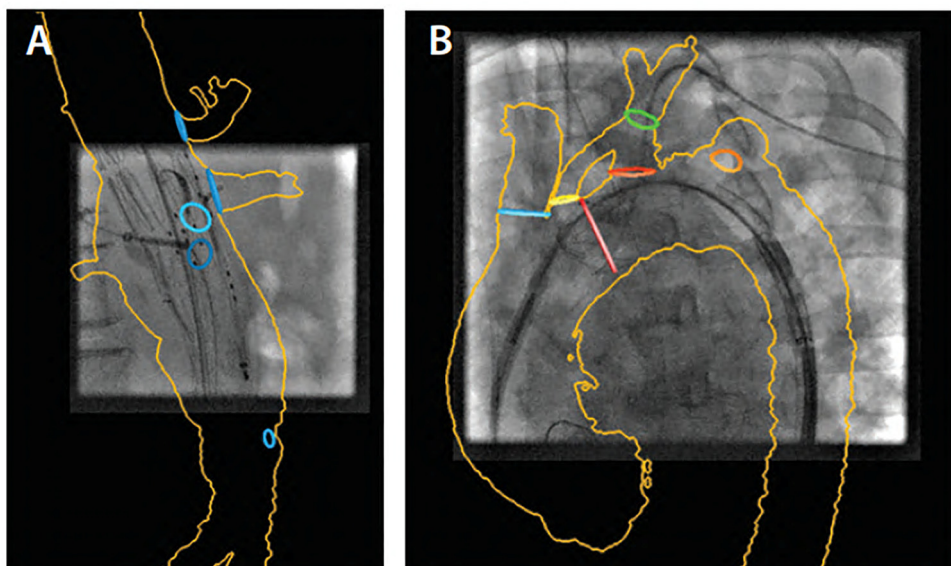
EVAR guided by image fusion (Discovery IGS 740 HOR equipped with EVAR Assist, GE Healthcare). The 3D model associates the aortic silhouette with the landmarks positioned by the operator. Graft landing zone and target visceral (A) and supra-aortic (B) vessel ostia are identified with planning circles, with optimal gantry angulations for their selection stored during planning and recalled from tableside for guidance. Several rendering modes and opacity options are available to display landmarks without obscuring live fluoroscopic visibility. Image fusion also allows gantry and table positioning without the use of x-ray, further reducing radiation exposure. By permission of Mayo Foundation and Springer Cham, Endovascular Aortic Repair, Gustavo S. Oderich, Chapter 8.
